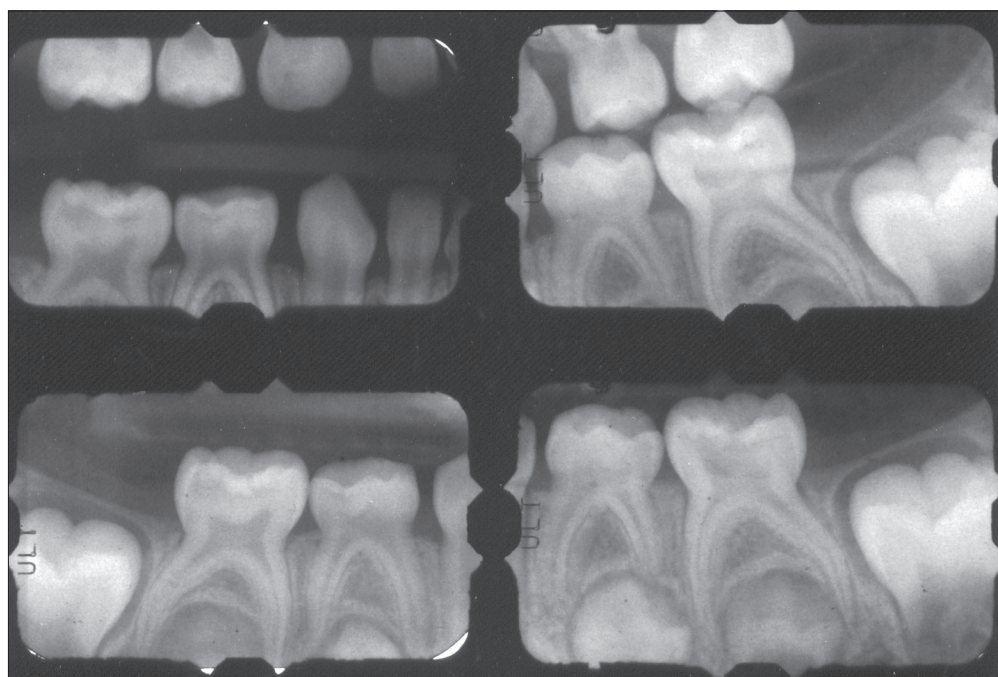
Intraoral radiographs
